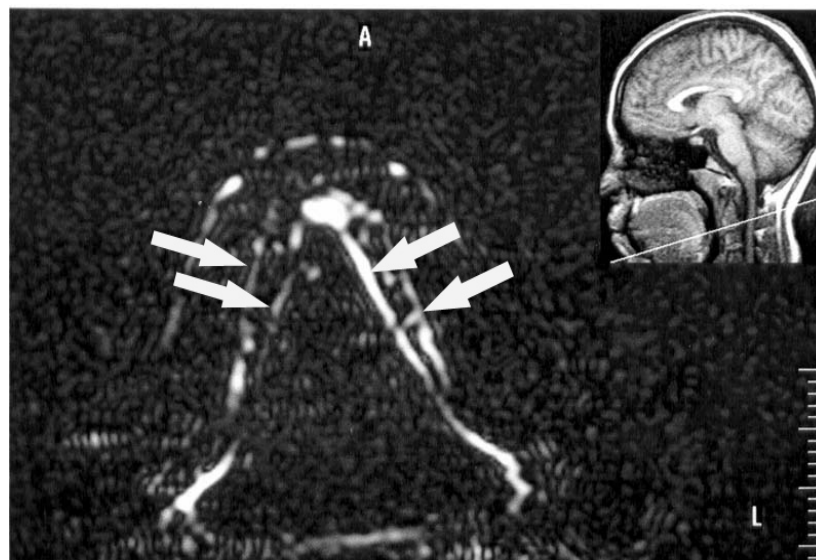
An MR sialogram, T2-weighted SSH axial cuts through the floor of the mouth showing bilateral submandibular duct duplication (arrow) terminating in a ranula.
